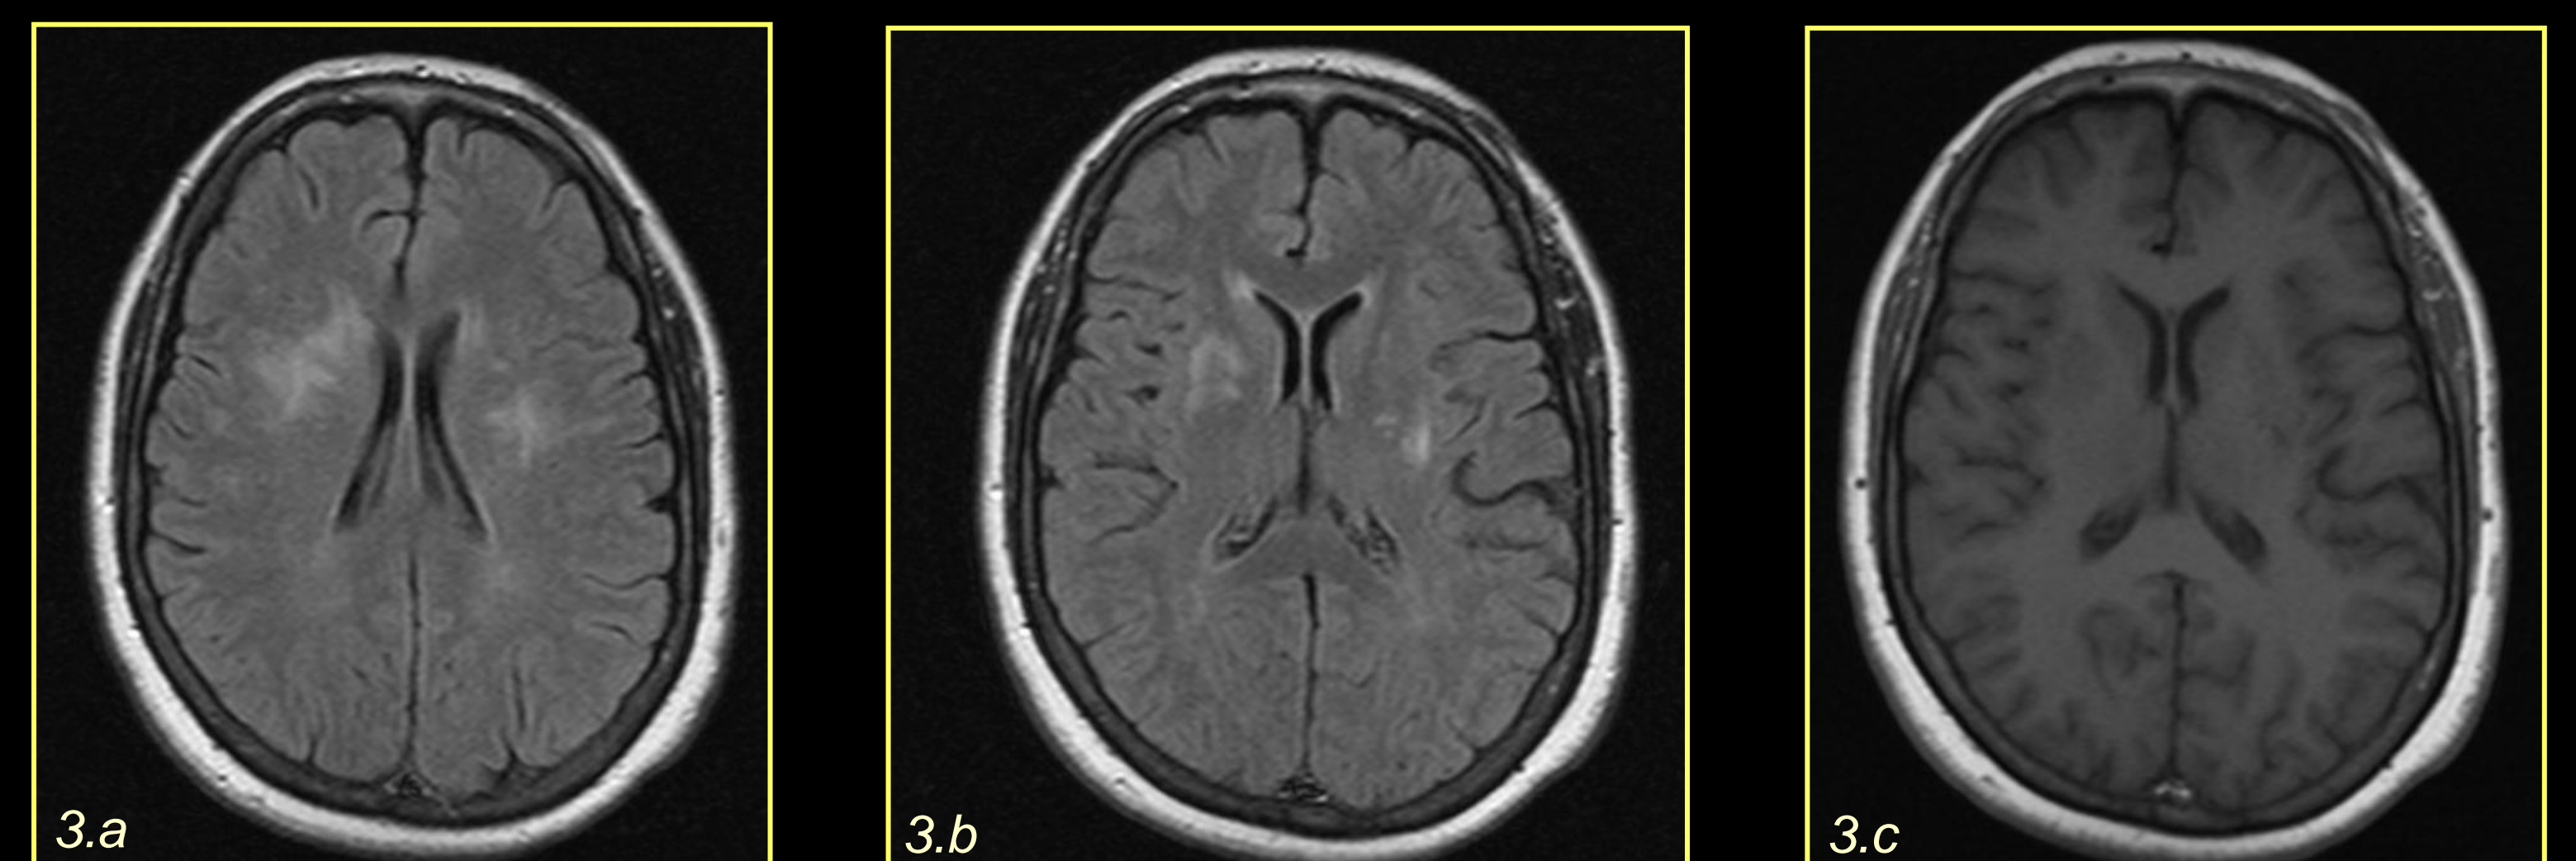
A 51-year-old woman with antiphospholipid syndrome. a) and b) Axial FLAIR images. c) Axial T1-WI.
